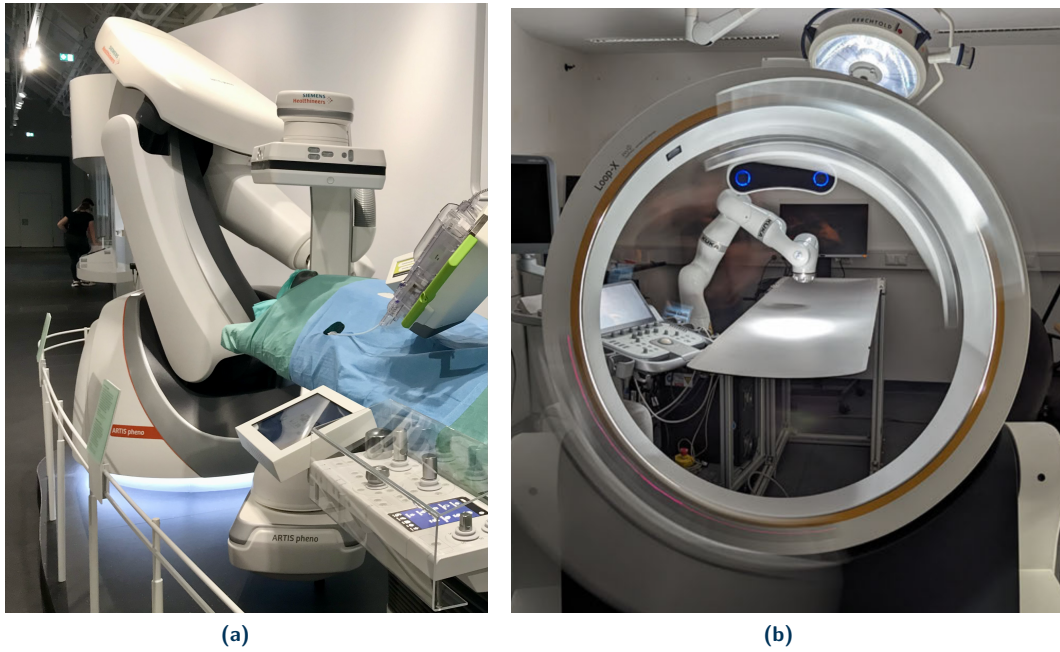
Fluoroscopic imaging modalities used in modern catheterization laboratories. (a) Robotically controlled C-arm fluoroscope from Siemens, and (b) Loop-X, a circular-shaped fluoroscope from Brainlab AG, capable of capturing cone-beam CTs.
